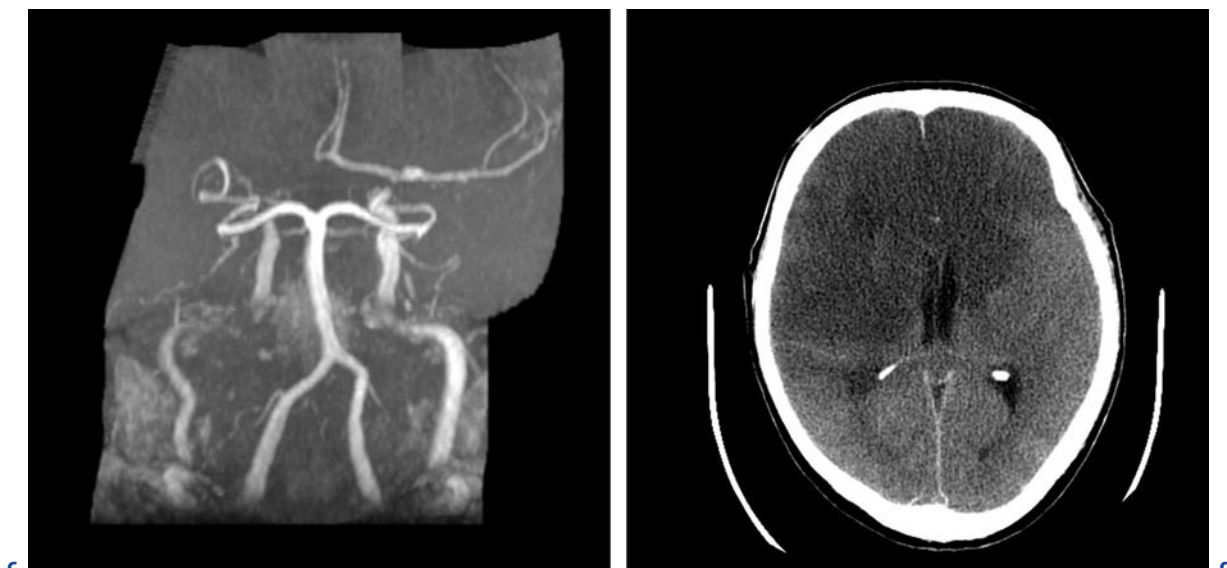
(continued) Luetic vasculitis. c,d Later stage of the disease: MIP of a arterial TOF MRA (c). Axial computed tomogram (d). Luetic vasculitis affects mainly the larger arteries of the circle of Willis and causes stenosis of the distal segments of both ICAs (b) followed by hemodynamic infarction in both hemispheres with restricted diffusion in the early stage
